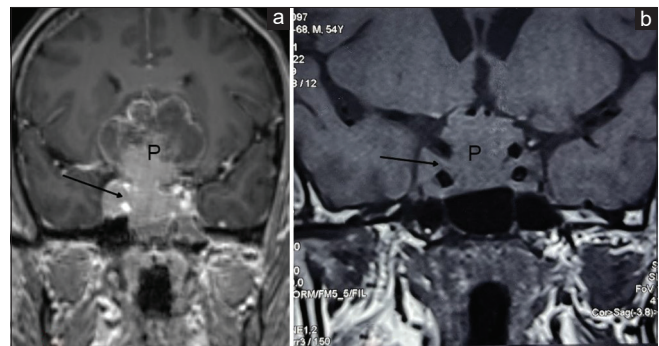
MRI image of a patient with giant macroprolactinoma: (a) Pre-treatment image showing large-sized pituitary adenoma (P) with bilateral Knosp grade IV invasion (black arrow) in the coronal T1W postcontrast image. (b) MRI image 6 months after treatment with cabergoline showing >50% reduction in tumour size (P) but persistent Knosp grade IV (black arrow) invasion
